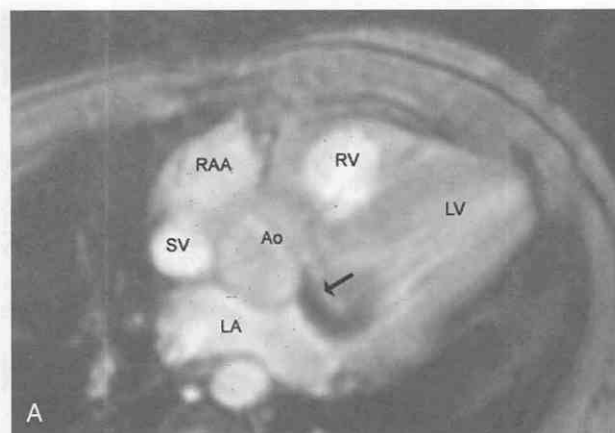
MR image obtained from a 30-year-old man with bicuspid aortic valve and aortic regurgitation. A, Diastolic oblique axial acquisition through the aortic valve (Ao) at the entry of the superior vena cava (SV) into the right atrium and the right atrial appendage (RAA). The signal void jet of aortic regurgitation (*arrow*) passes along the anterior mitral leaflet and strikes the posterior left ventricular (LV) wall. LA, left atrium; RV, right ventricle. B, In this diastolic short-axis image, the signal void jet is seen in cross-section (*arrows*). RV, right ventricle.
